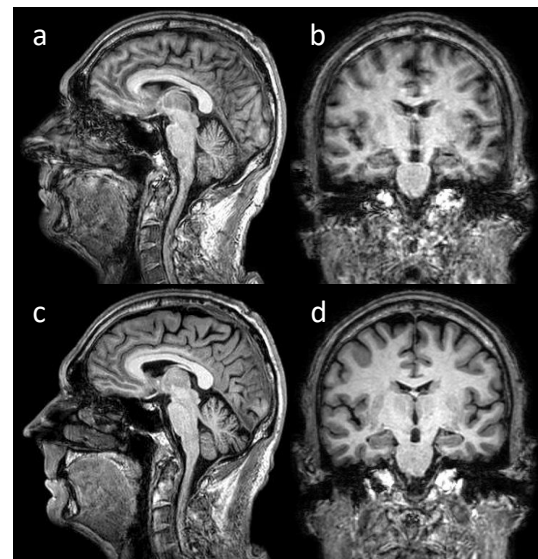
T1-weighted 3D IR-TFE scan of subject with medium pose changes during scan. (a/b) Scan without PMC. (c/d) Scan with PMC enabled.
